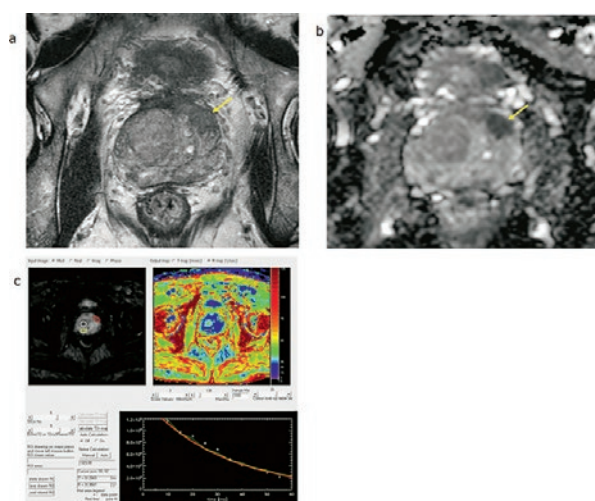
MRI of the prostate T2W (a.), DWI (b.), BOLD (c.)
